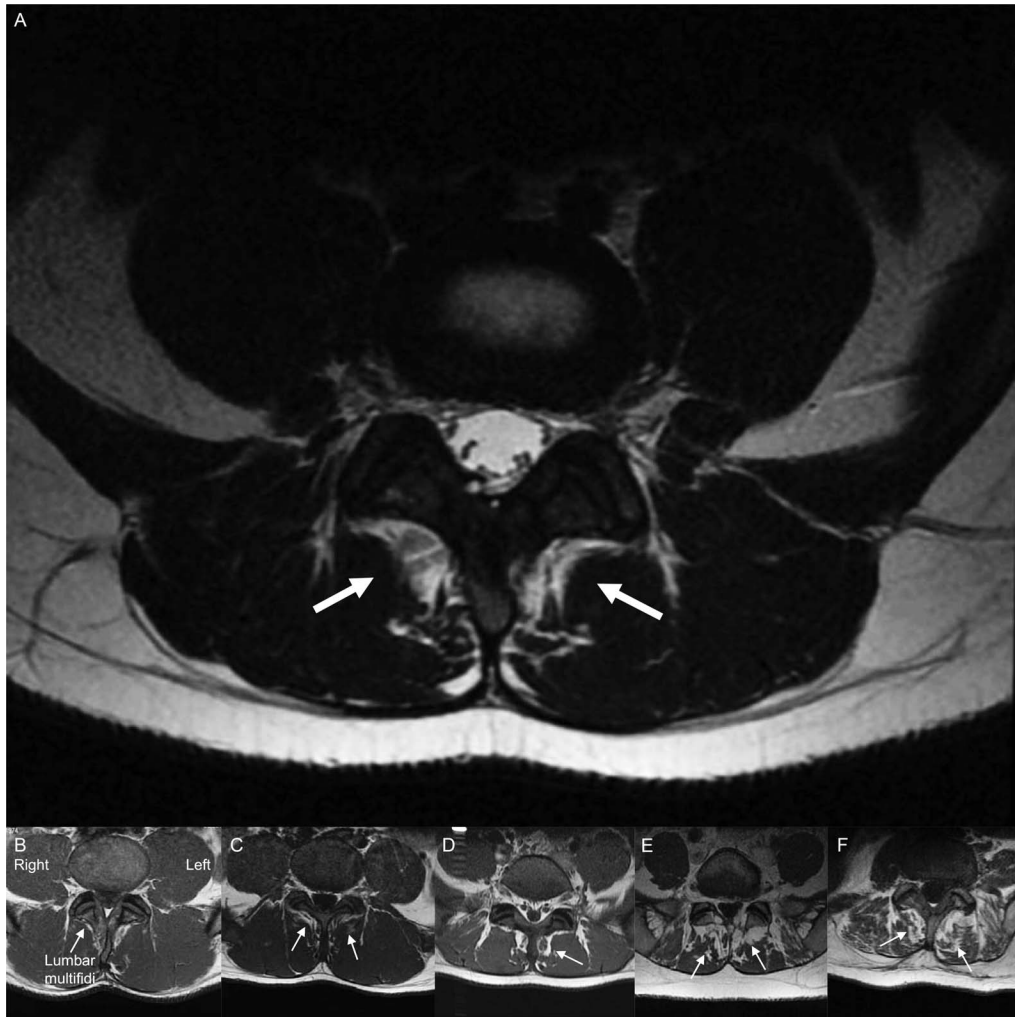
A, Lumbar spine magnetic resonance imaging scan of a 15-year-old high school gymnast demonstrating lumbar multifidus muscle atrophy with fatty infiltration (Goutallier grade 2). Examples of B, Goutallier grade 0 (right unilateral), C, Goutallier grade 1 (bilateral), D, Goutallier grade 2 (bilateral), E, Goutallier grade 3 (bilateral), and F, Goutallier grade 4 (bilateral). Parts B–F are reprinted from Winslow J, Getzin A, Greenberger H, Silbert W. Fatty infiltrate of the lumbar multifidus muscles predicts return to play in young athletes with extension-based low back pain. *Clin J Sport Med*. Published online ahead of print August 18, 2017, <http://journals.lww.com/cjsportsmed/pages/default.aspx>, with permission.
